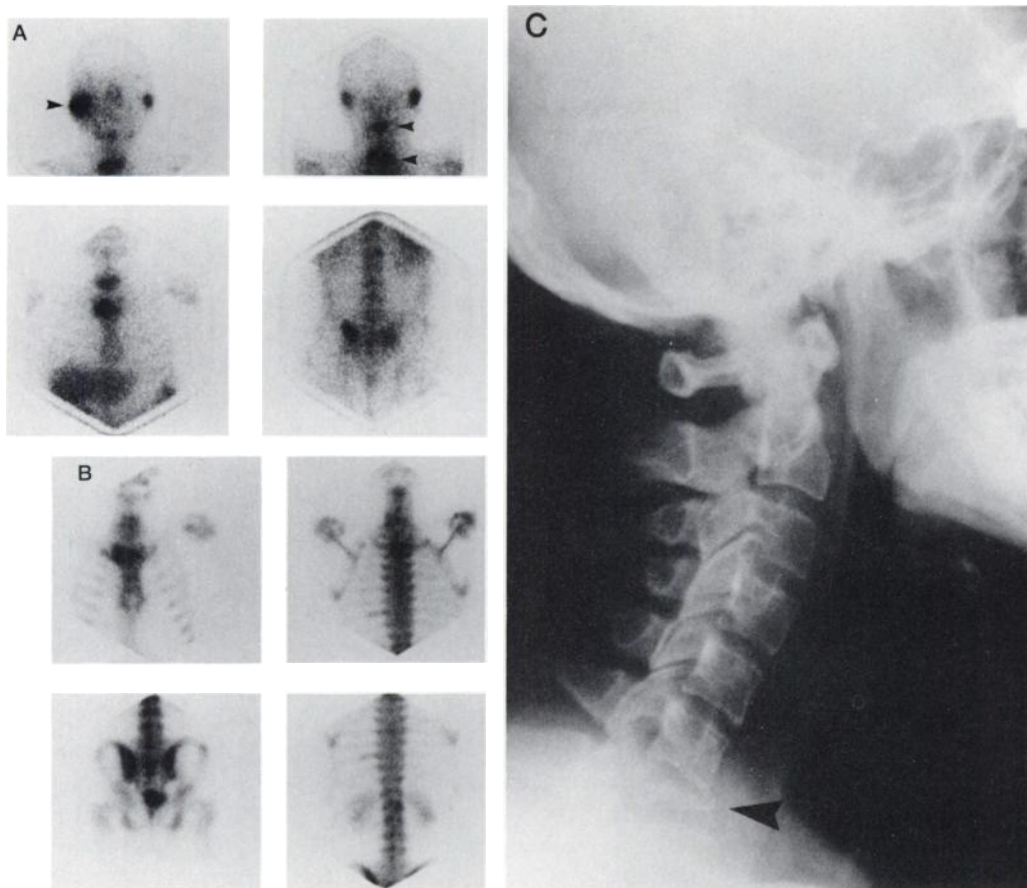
Tuberculous spondylitis. (A) Intense ^{67}Ga accumulation is noted in the right periauricular region on the anterior view of the head (arrow, left upper frame) with equally intense ^{67}Ga uptake at C3 and C7 on the posterior images of the head and neck areas (arrow, right upper frame). Gallium-67 uptake in the sternum indicates sternal osteomyelitis on the anterior view of the thorax (left lower frame). Intense ^{67}Ga accumulation in the left sacro-iliac joint and milder uptake on the right side of the L1 indicate further dissemination of the tuberculous infection (right lower frame). After therapy, all ^{67}Ga images reverted to normal. (B) On the bone scan, increased uptake of $^{99\text{m}}\text{Tc-MDP}$ is noted in the sternum (left upper frame) with only mild accumulation at C3 and C7 (right upper frame). The left sacroiliac joint has a normal appearance (left lower frame) and mild $^{99\text{m}}\text{Tc-MDP}$ uptake is present on the right side of L1 (right lower frame). (C) Lateral radiographs of the C spine at the time of diagnosis show destruction of C7 (arrow), whereas C3 has a normal appearance.
